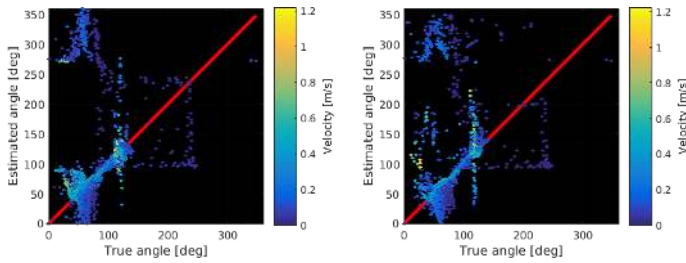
Scatter plots of true (CFD) angles versus ultrasound estimations of angles at peak systole. Estimates from TO (left) and TO-DB (right) color encoded with estimated velocity.
